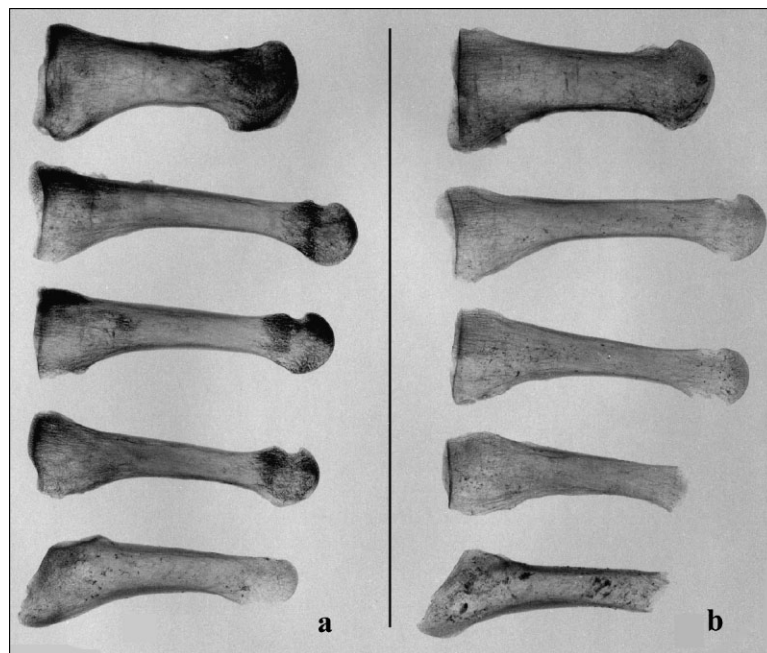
Medial-lateral radiographs of (a) left and (b) right metatarsals.
